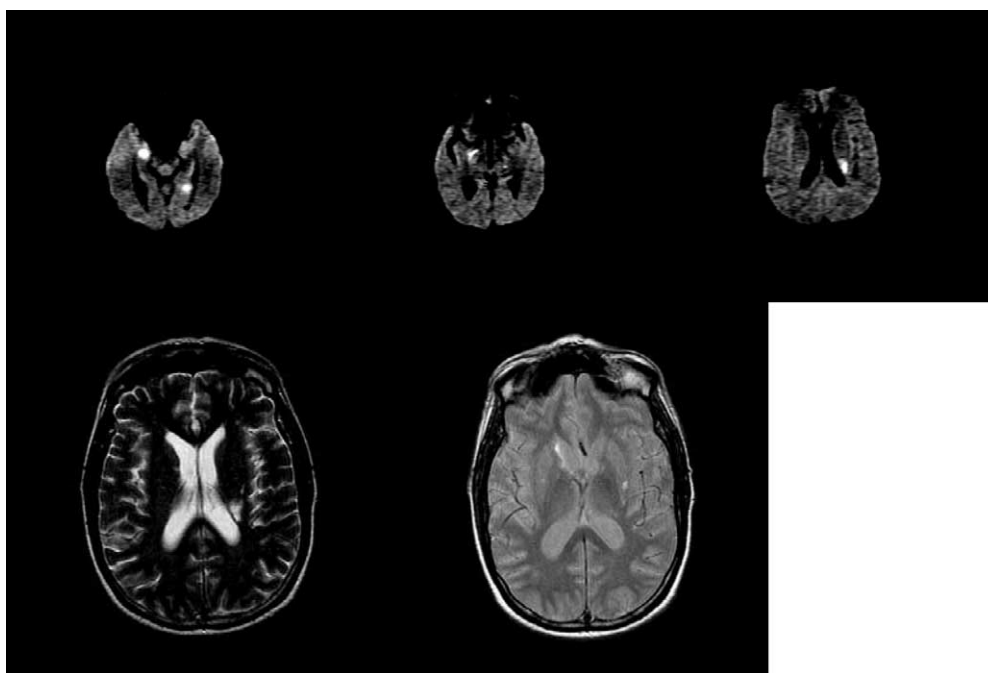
A 59-year-old man, without known vascular and HIV risk factors, was admitted to the hospital for acute onset of left hemiparesis. Diagnostic work-up revealed HIV1+ and AIDS disease criteria were found to be present. His brain MRI showed multiple ischemic lesions (axial diffusion, T2-weighted, and flair scans).
